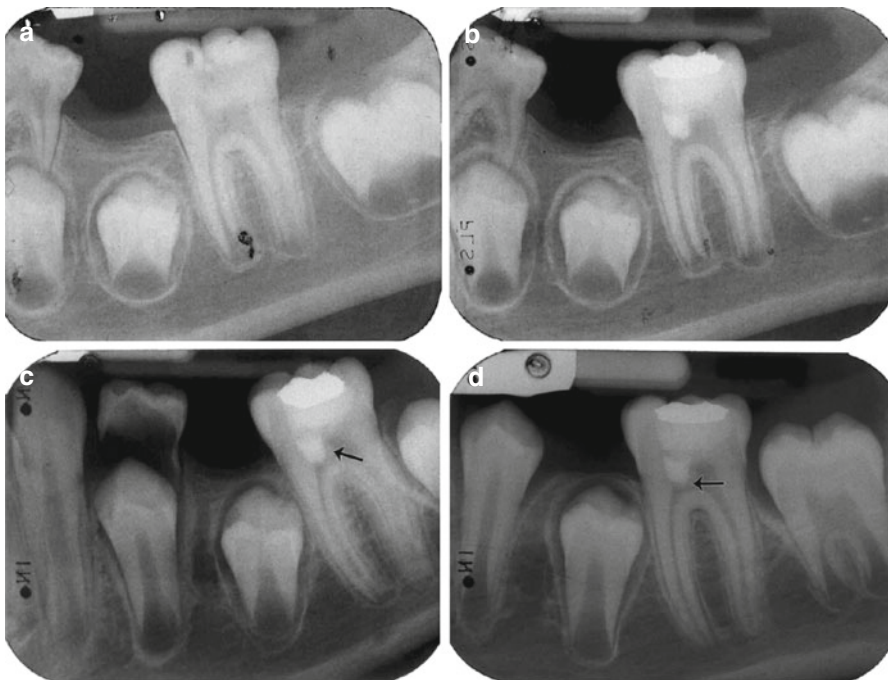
(a) Preoperative periapical radiograph showing deep carious lesion in the mandibular first molar. (b) Postoperative radiograph taken immediately after treatment with partial pulpotomy and MTA. (c) Tooth: 16 months after treatment. Notice dentine bridge formation in the mesial side of the tooth (*arrow*). (d) Tooth: 26 months after treatment. Notice the well-formed dentinal bridge (*arrow*) and the physiological continuation of root formation (Reprinted from Barrieshi-Nusair and Qudeimat [37]; with permission)
